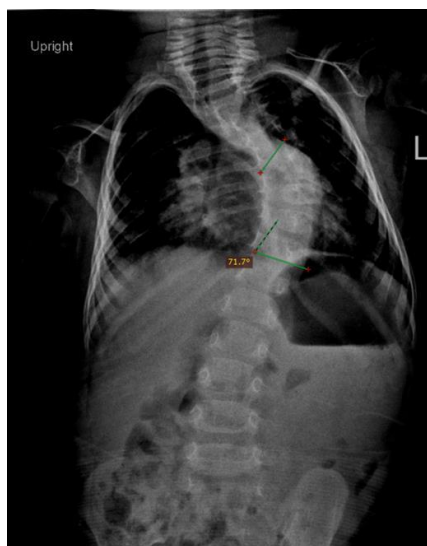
Initial standing radiograph at presentation showing a double thoracic curve measuring > 60°.
